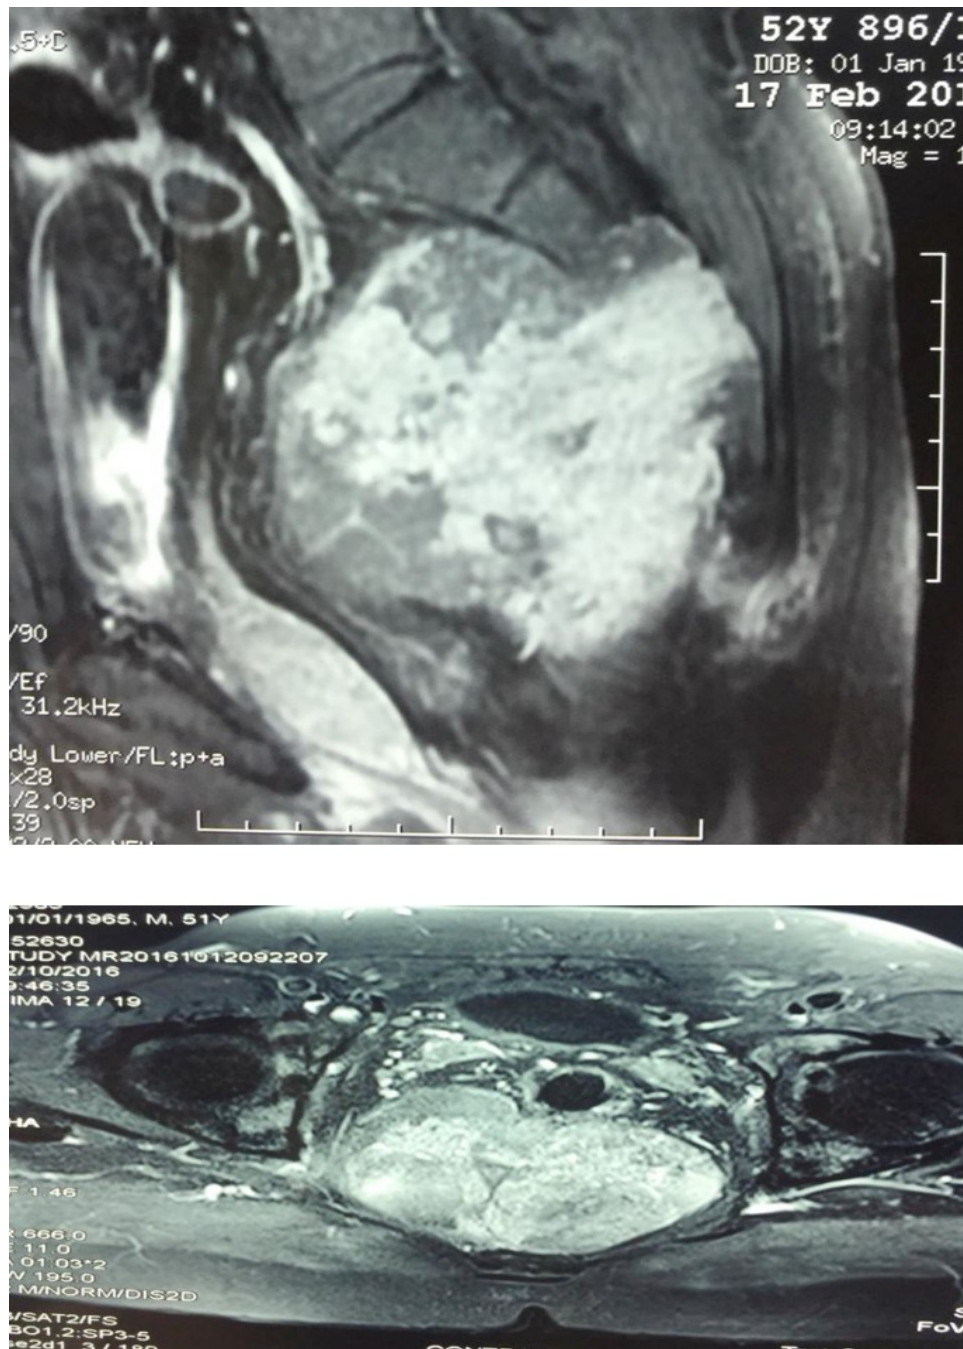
CT in transverse and sagittal sections showing the sacral tumor
